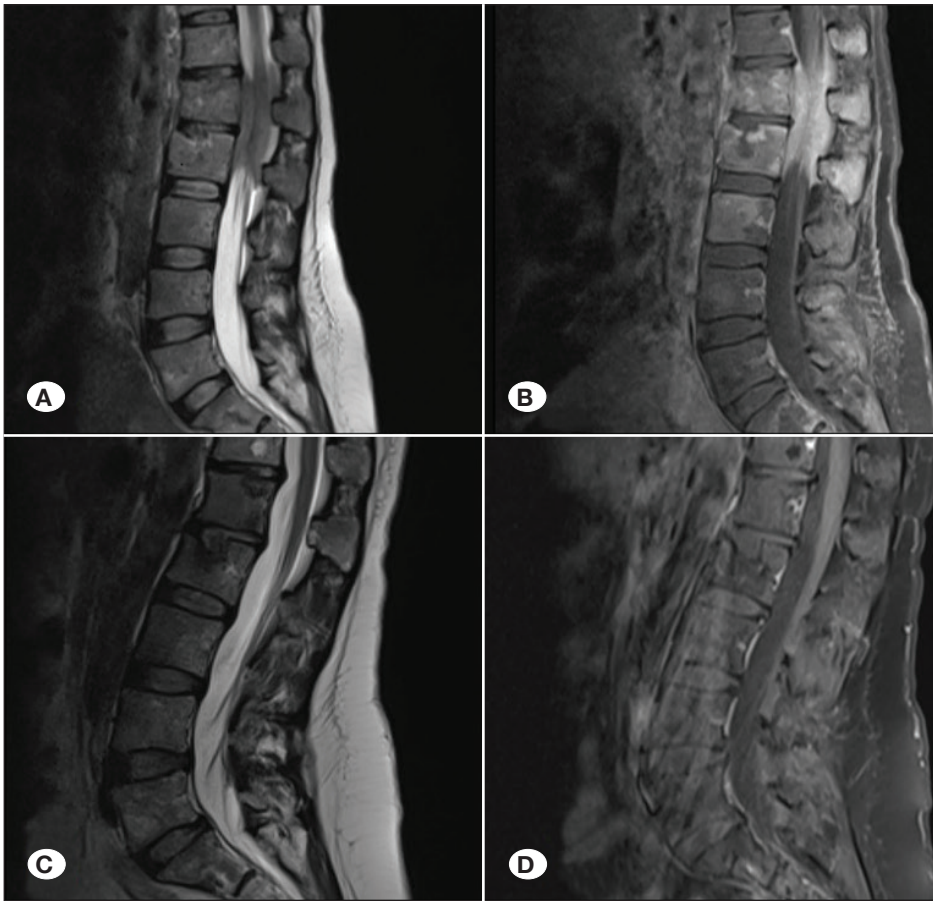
Sagittal T2 weighted (A) and post-contrast T1 weighted MR images (B) of a case with low back pain showed presence of tumor at the level of L1-2. PB confirmed presence of lymphoma and patient referred to the hematology. Five years later MR images showed no tumor at sagittal T2 weighted (C) and post-contrast T1 weighted MR images (D).
